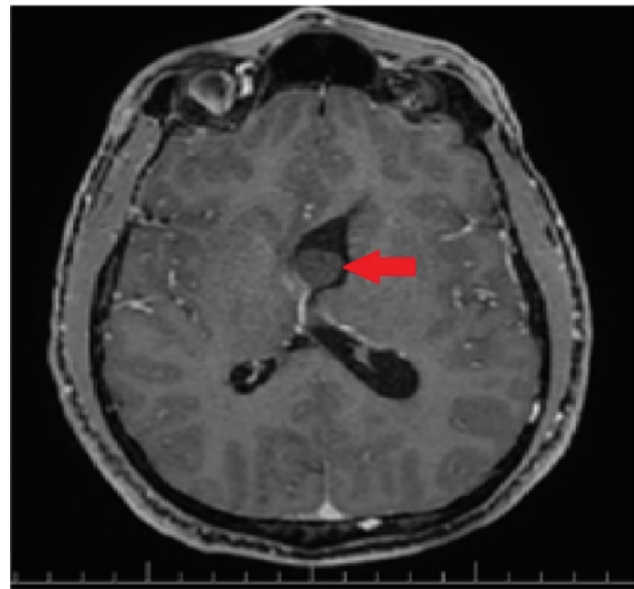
Preoperative contrast-enhanced T1-weighted axial brain magnetic resonance imaging scan showing a mild, contrast-enhancing, well-demarcated solid lesion extending from the third ventricle to the left lateral ventricle, with a diameter of 22 × 28 mm, and unilateral acute hydrocephalus (red arrow).
